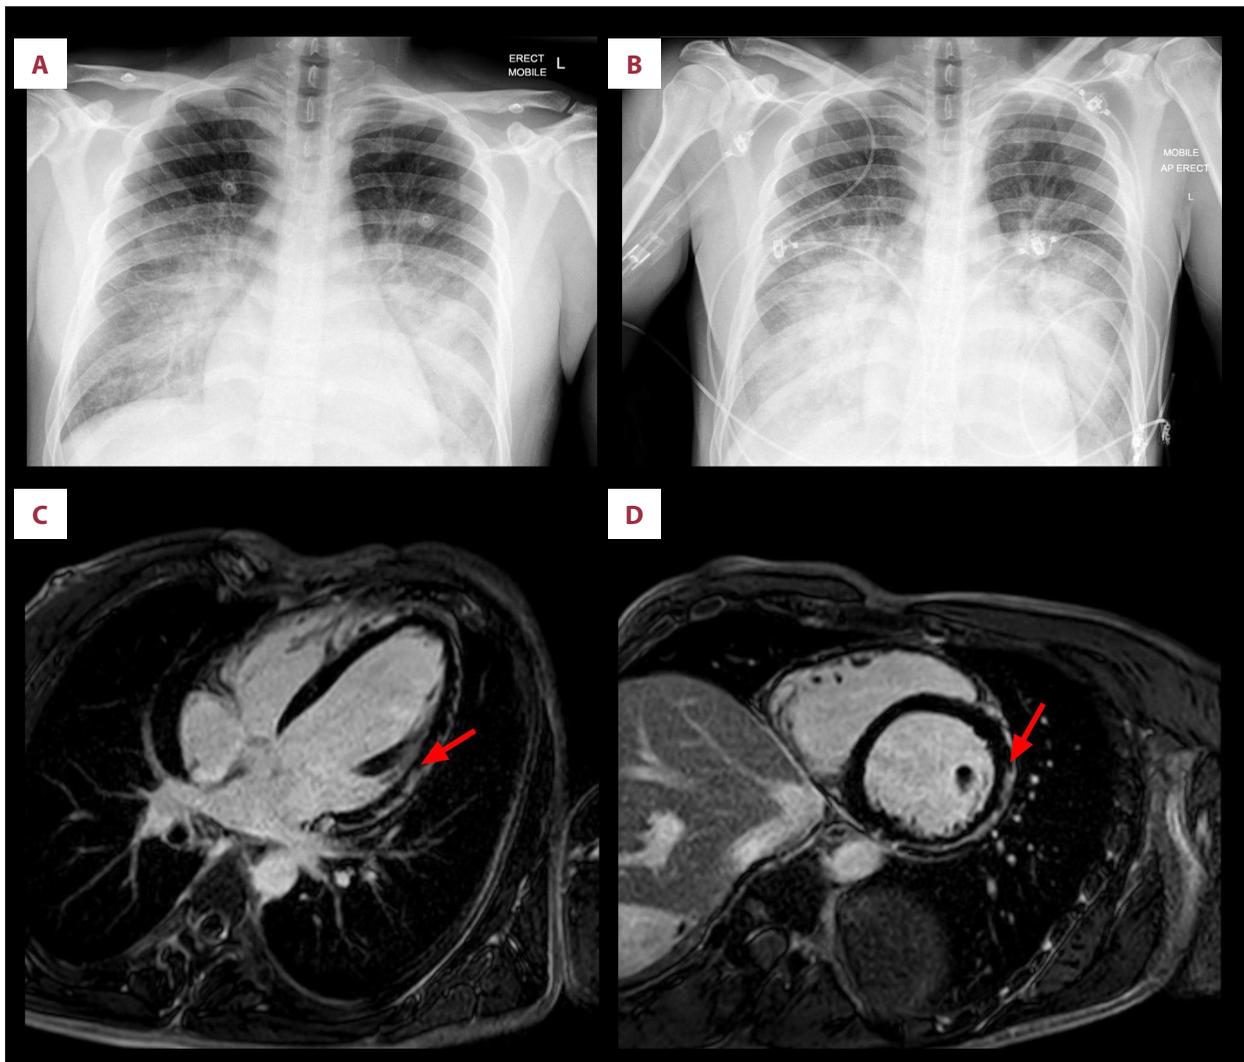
Chest X-ray and cardiac MRI investigations performed during the patient's hospital admission. (A) PA chest X-ray shows no evidence of cardiomegaly. A small, non-specific right lower lobe pulmonary infiltrate was noted. (B) Progressive AP chest X-ray shows extensive infiltrates in the middle and lower zones consistent with acute pulmonary edema. (C, D) Cardiac MRI shows low-grade, subepicardial enhancement at the lateral aspect of the lateral ventricular wall, which was more pronounced on the basal to middle portions of the left ventricle (arrows). These features were suggestive of a viral myocarditis. AP – anterior-posterior; PA – posterior-anterior.
